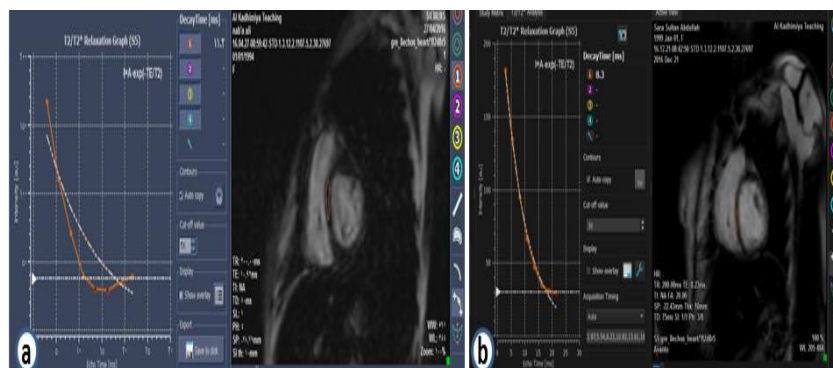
a: 20 years old female patient presented with fatigability with beta-thalassemia major, MRI shows a moderate cardiac iron deposition, MIC=2.36mg/gm. b: another 27 years old female patient with thalassemia major presented with shortness of breath, MRI shows a severe cardiac iron deposition, MIC=3.4mg/gm.
